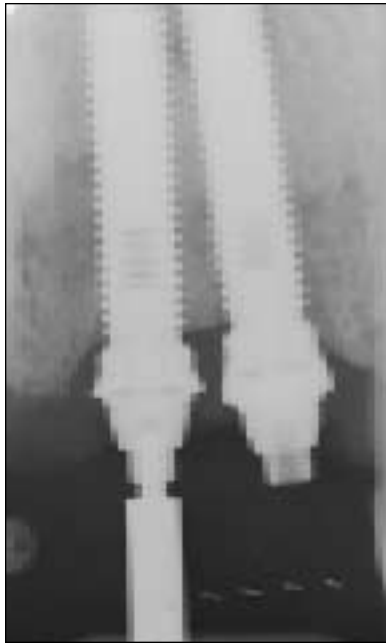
(Left) Radiograph taken to verify the fit of an abutment and the quality of the surrounding bone. A guide pin has been screwed into the abutment screw and inserted into the hole of the film holder. The result is an orthogonal projection.
